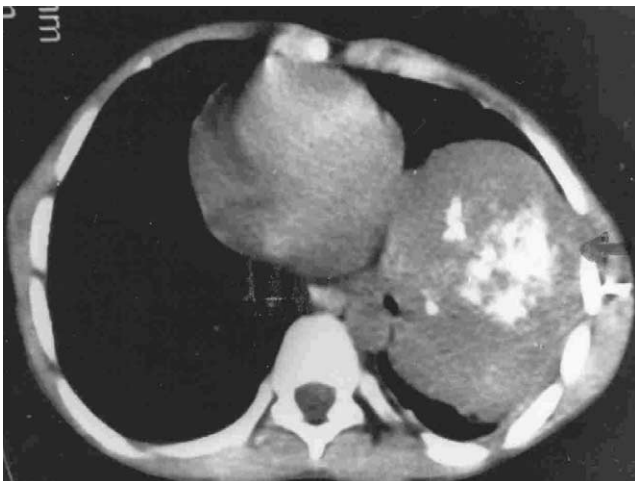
CT scan showing homogenous well circumscribed lesion.
